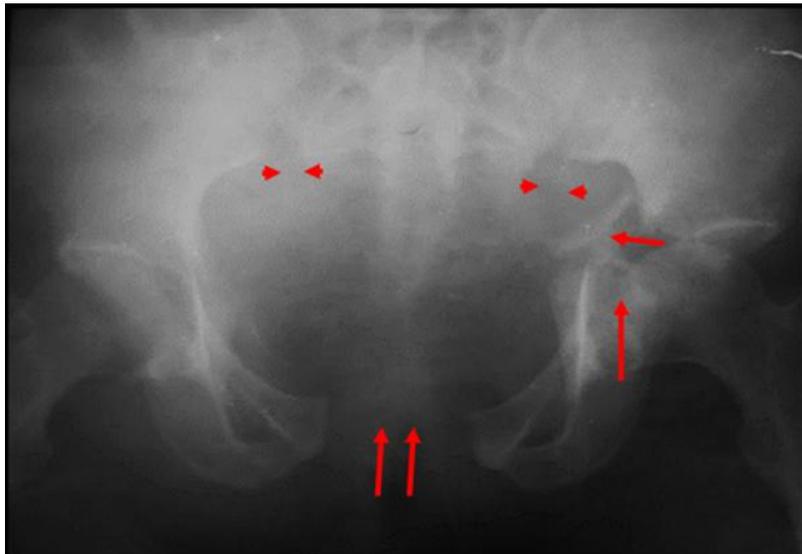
Plain x-ray of the Pelvis, AP view showing Anteroposterior compression fracture shows a Combined / Complex Acetabular fracture of the left hemipelvis (single vertical arrow), with detached fragment medially displaced into the pelvis (horizontal arrow), wide diastasis of the pubic symphysis (vertical arrows) and bilateral sacroiliac diastases (arrowheads) "open book" fracture
